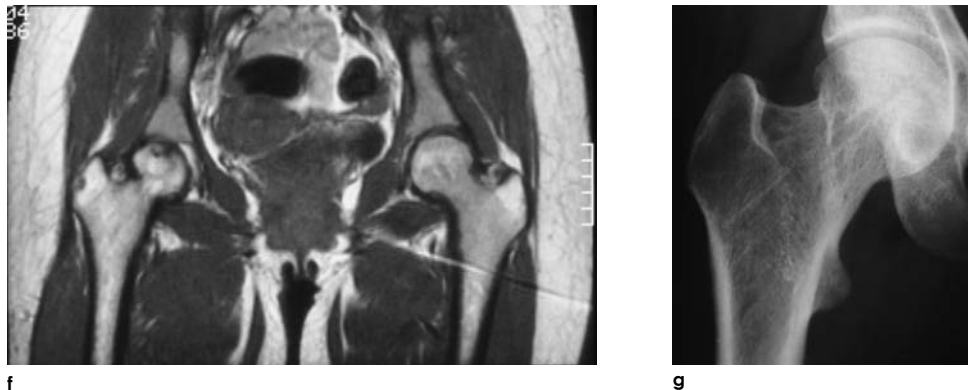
Missed femoral neck fracture in a polytraumatized patient due to inadequate radiographs.
